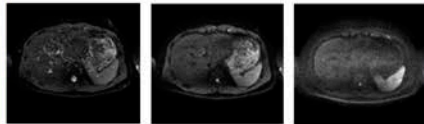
Axial slices of DWI acquisition in a healthy volunteer with  $b$ -values of 0, 100 and 1000  $s/mm^2$  (from left to right).
